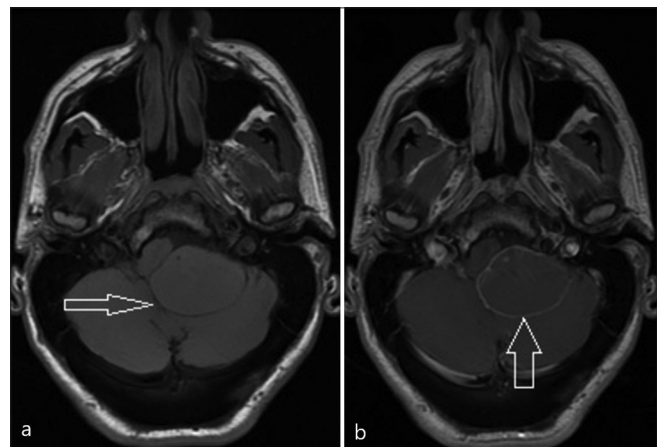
(a) Isointense signal on T1-weighted images at the left cerebellopontine angle, causing mass effect (arrow) to brainstem and cerebellum. (b) Post IV contrast thin marginal enhancement (arrow) with mildly thickened septae at the lower anterior part.
